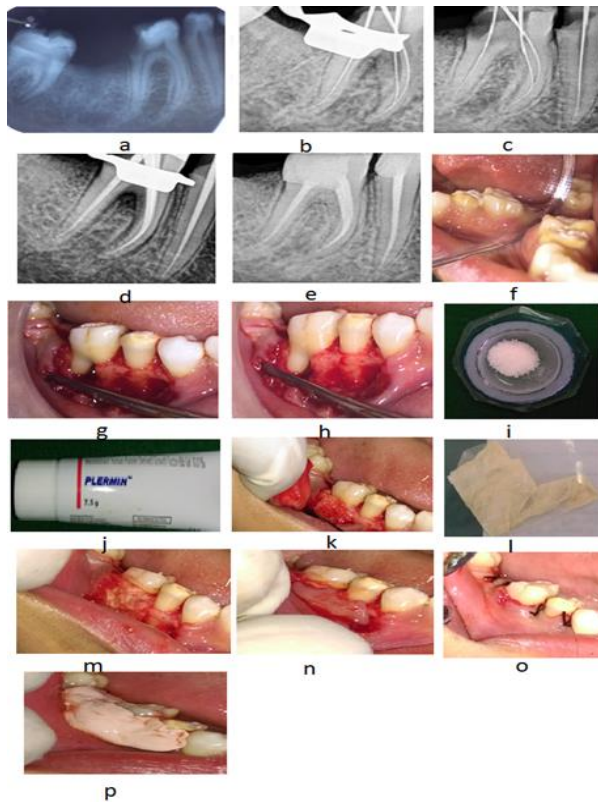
a: Pre-operative Radiograph; 1.b, 1.c: Working length Radiograph; 1.d: Master Cone Radiograph; 1.e: Obturation Radiograph; 1.f: Temporary Restoration in 45 & 46; 1.g: Defect area in tooth 46; 1.h: Intrabony Defect after Complete Degranulation and Debridment; 1.i: Bone Graft; 1.j: rhPDGF; 1.k: Placement of bone graft and rhPDGF in the defect area; 1.l: Chorion membrane; 1.m: Membrane placement in the defect area; 1.n: position of the flap; 1.o: flap secured with suture; 1.p: Periodontal Dressing.
